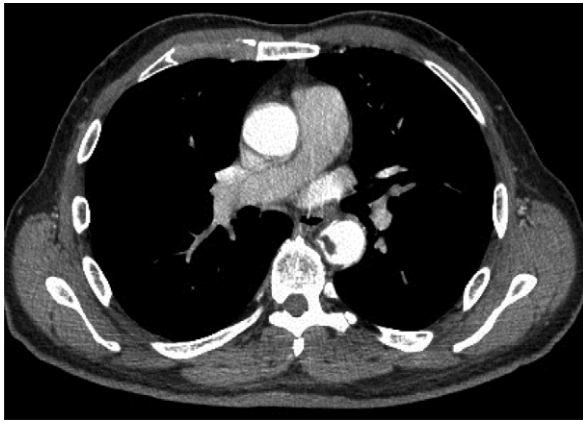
Computed tomography (CT) scan with intravenous contrast showed a mobile thrombus attached to the medial wall of the descending thoracic aorta.
